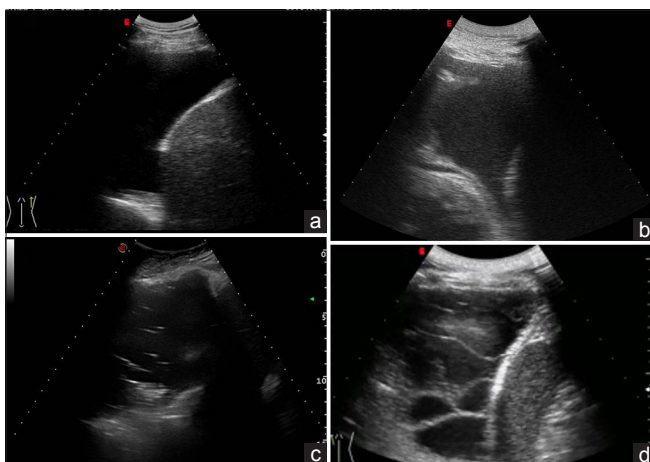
Transthoracic ultrasound pleural effusion patterns: (a) anechoic, (b) homogeneously hyperechoic, (c) complex nonloculated, (d) complex loculated
